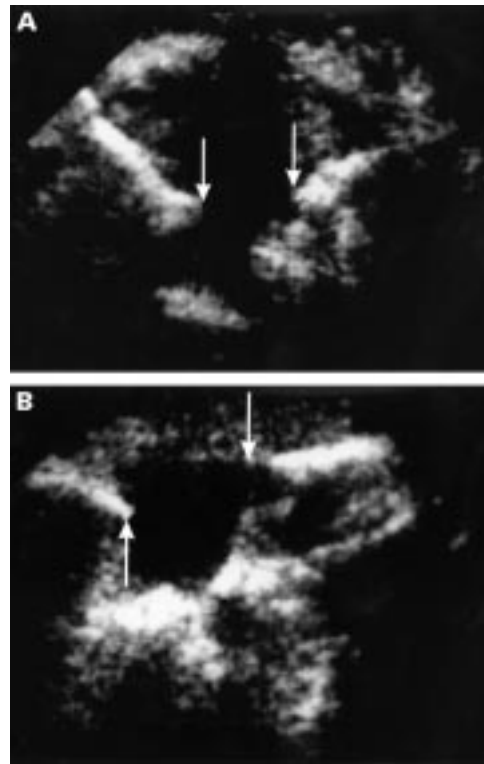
B mode ultrasonogram of the soft tissue anastomosis at 2 weeks after surgery (case 6) showing (A) the anteroposterior dimensions (8.0 mm; between arrows) and (B) the vertical dimensions (9.0 mm; between arrows).
